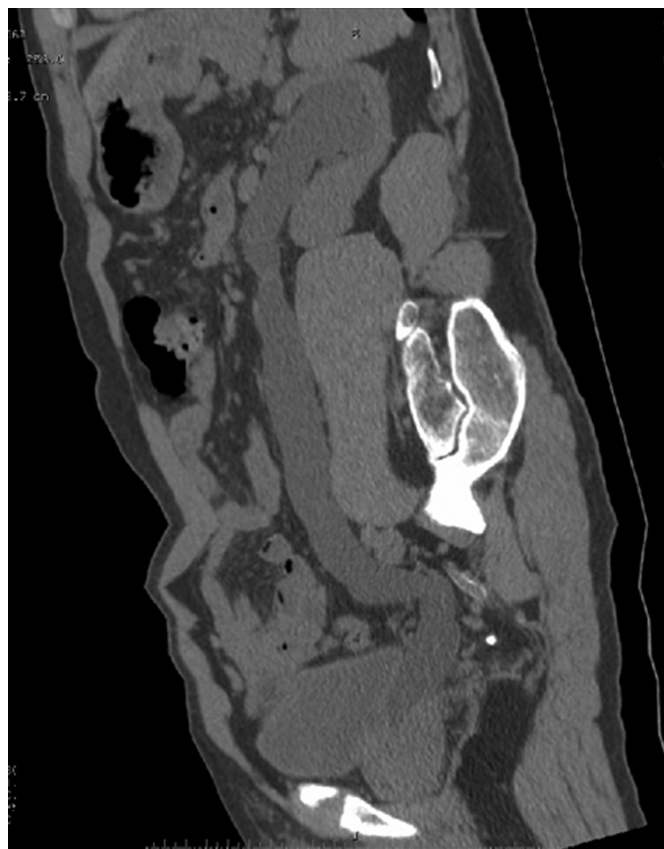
Sagittal reconstructed computed tomography images, demonstrating a left duplicated collecting system. Of note, there is a hydronephrotic upper pole with preserved renal parenchyma and a dilated ureter to the level of its ectopic insertion into the prostatic urethra.
